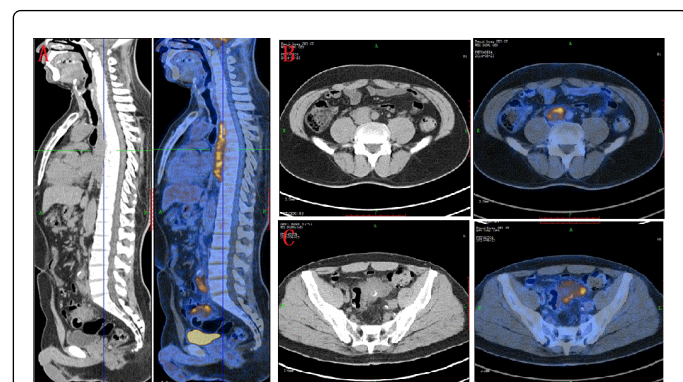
PET/CT fusion image showed the SUV information about the mass (A). Near to the right arteria iliaca communis there was a thickening soft tissue (B). The image showed that beside the colon sigmoideum there was a soft tissue (C).
